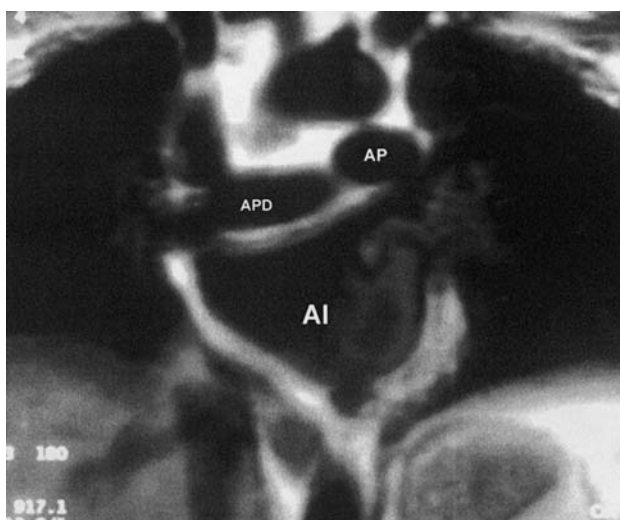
Magnetic resonance imaging (coronal section) showing the relation between the right pulmonary artery (RPA) and left atrial cephalad face.
